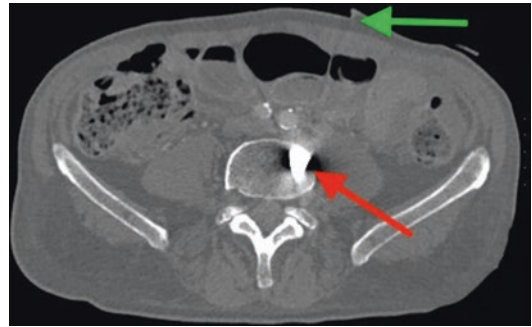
Axial CT with bone reformats through the abdomen demonstrates a very high density triangular object in the vertebral body (red arrow), which represents the broken off tip of a knife blade responsible for a penetrating abdominal injury wedged in the bone. A skin defect at the entry site in the anterior left abdominal wall is visible (green arrow)
